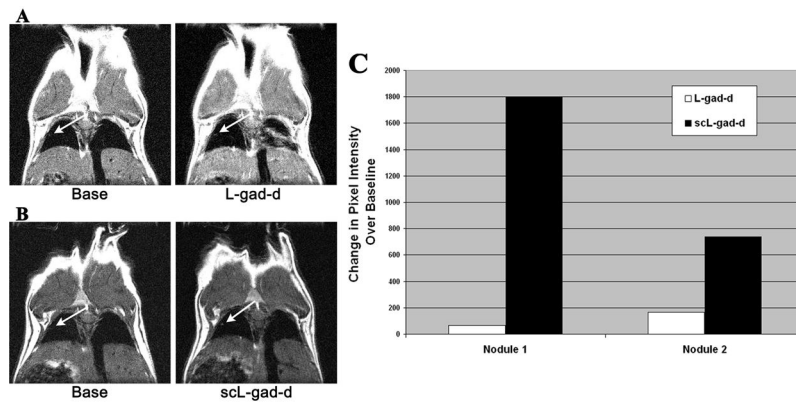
Comparison of MR image enhancement between targeted and unliganded complex
